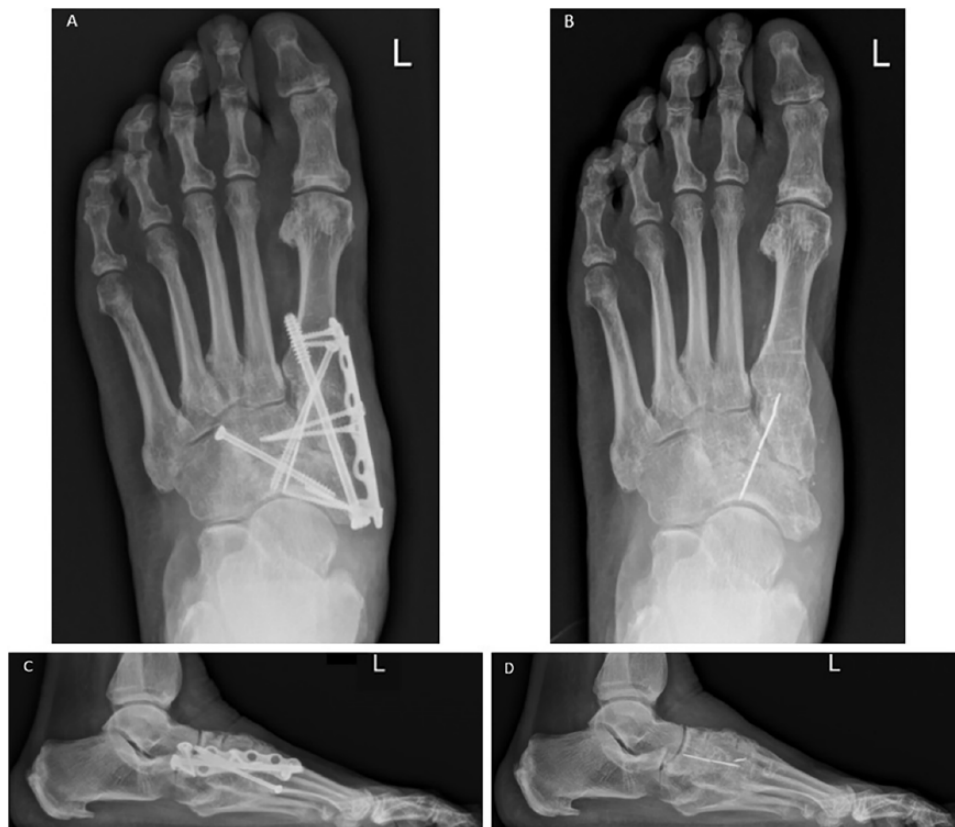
(A) Anteroposterior (AP) radiograph of the foot before removal of hardware; (B) AP radiograph after removal of hardware; (C) lateral radiograph of the foot before removal of hardware; (D) lateral radiograph after removal of hardware.
